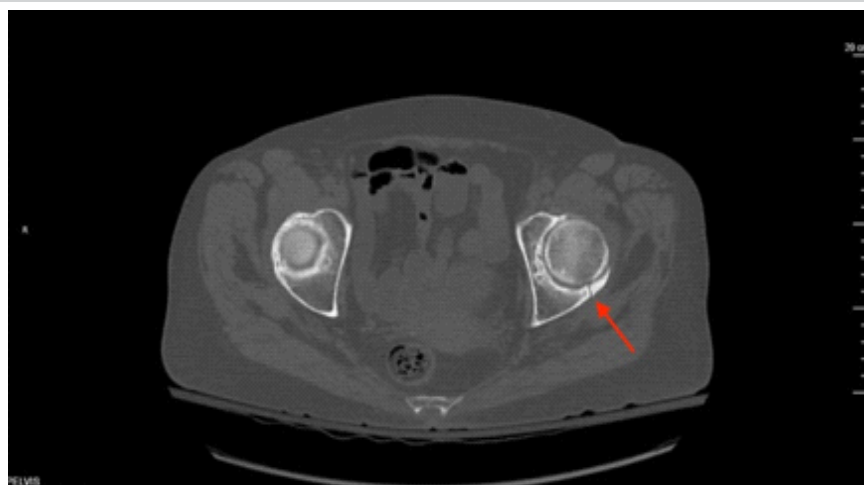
Axial computed tomography of the pelvis showing left posterosuperior acetabular fracture. Computed tomography of the pelvis without contrast (March 7, 2024). Axial reconstructions demonstrate a linear fracture of the posterosuperior aspect of the left acetabulum without significant displacement. Surrounding sclerosis is noted. Moderate bilateral hip osteoarthritis is visible.
